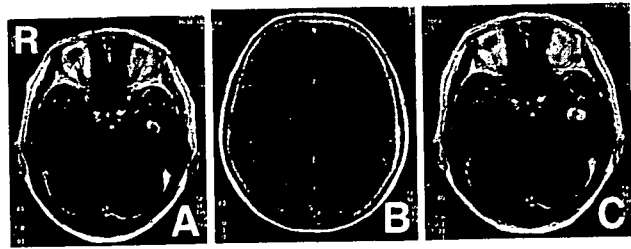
T₁-weighted magnetic resonance images with contrast medium showing tumor shrinkage after two cycles of high-dose methotrexate therapy (A, B), and tumor enlargement after three cycles (C).
